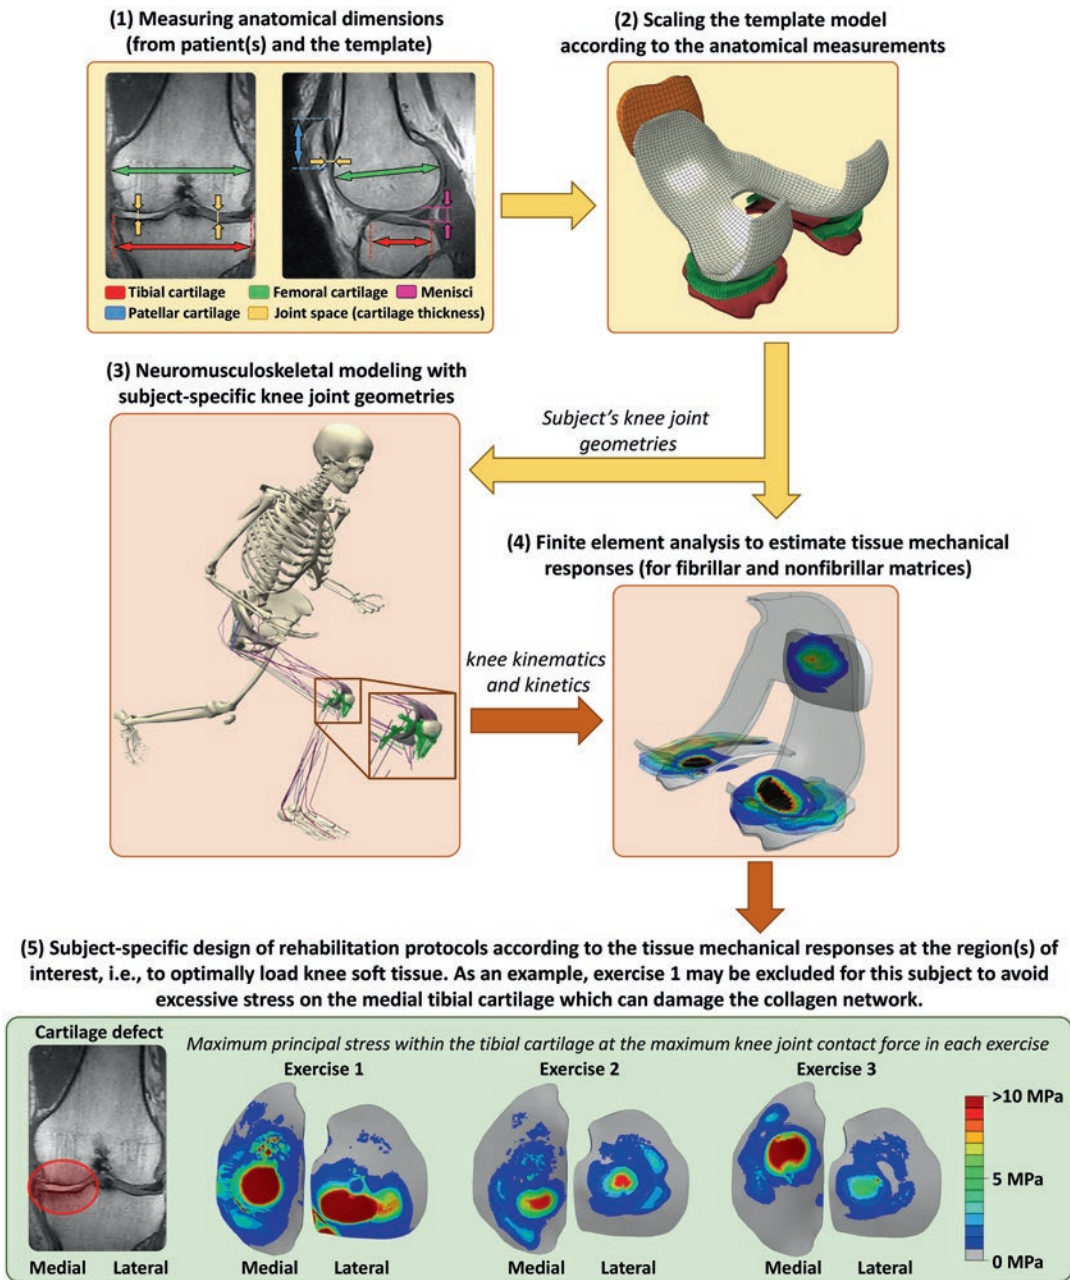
Atlas-based rapid MS-FE modeling, toward a clinical assessment tool to aid decision making. (1): Anatomical dimensions are measured from subject’s and the template’s medical images, such as MRI. (2): The template FE model (*i.e.*, meshed geometries) are anisotropically scaled according to the anatomical dimensions. Note that the template FE model contains the fibril-reinforced poroviscoelastic material model, contact pairs, *etc.*, enabling rapid generation of the subject’s FE model. (3): Neuromusculoskeletal modeling is used to estimate subject’s kinematics, muscle forces, and joint contact forces to provide the FE model with subject-specific inputs. The MS model can incorporate subject’s muscle activation
